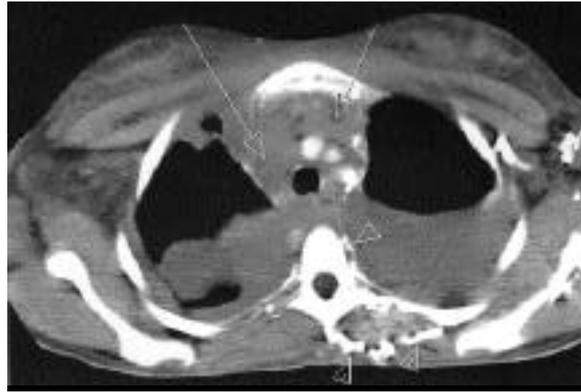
Axial chest CT scan at the level of 5 vessels (mediastinal window): a large amount of bilateral pleural effusion is seen, left brachiocephalic vein and superior vena cava are not opacified (arrows) due to thrombosis, multiple collateral vessels are shown (arrowheads).
